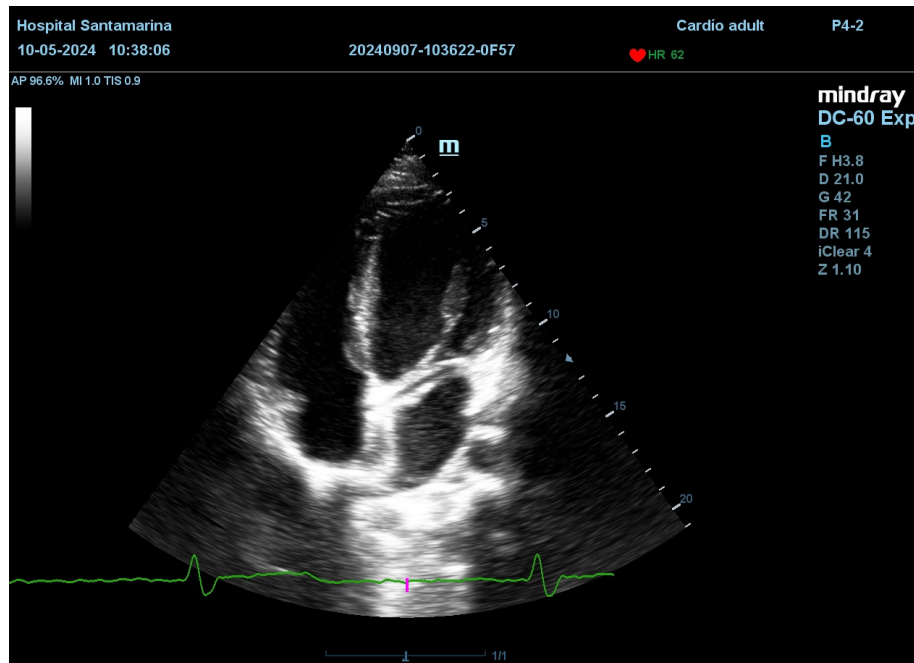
Apical four chambers view showed the retroaortic circumflex (RAC) sign.
